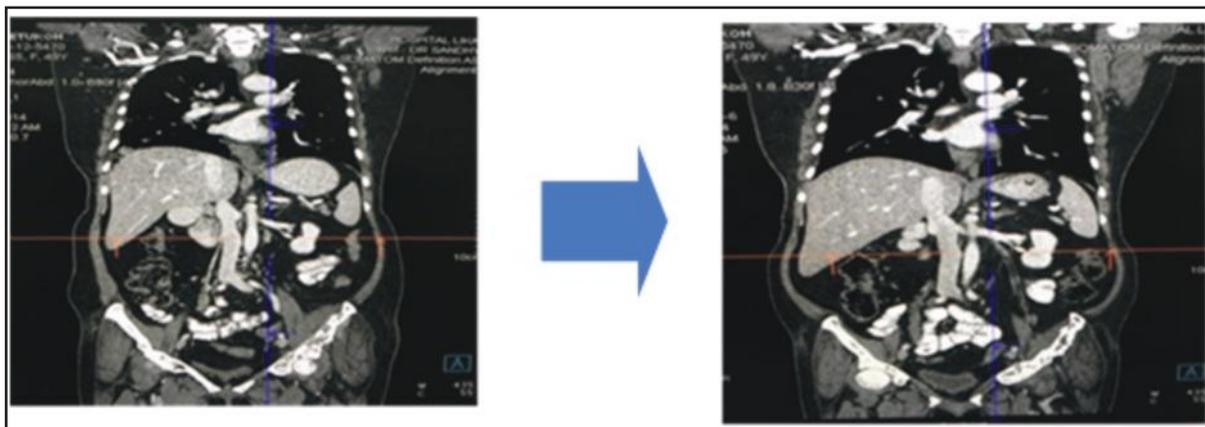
Coronal CT at baseline and 3 months after eribulin showing resolution of para-aortic lymphadenopathy.
